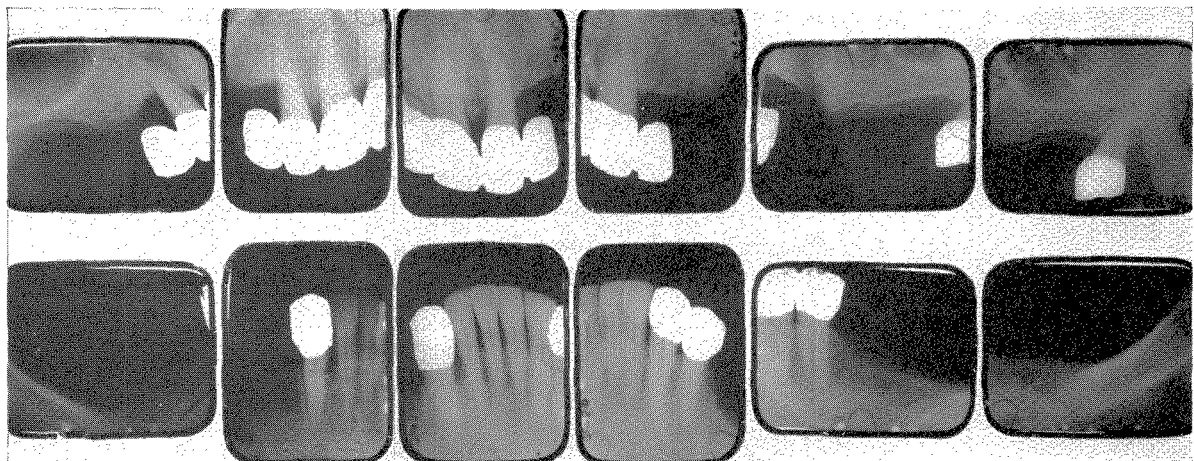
These are the roentgenograms taken in March, 1962, six years after the upper prosthesis was inserted.
